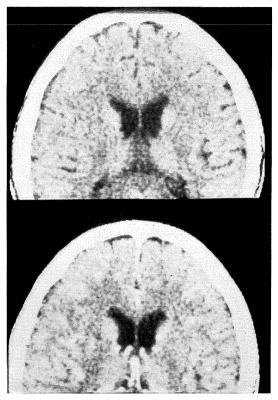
CT scans on the 64th day after onset. Plain CT (upper) and enhanced CT (lower).
